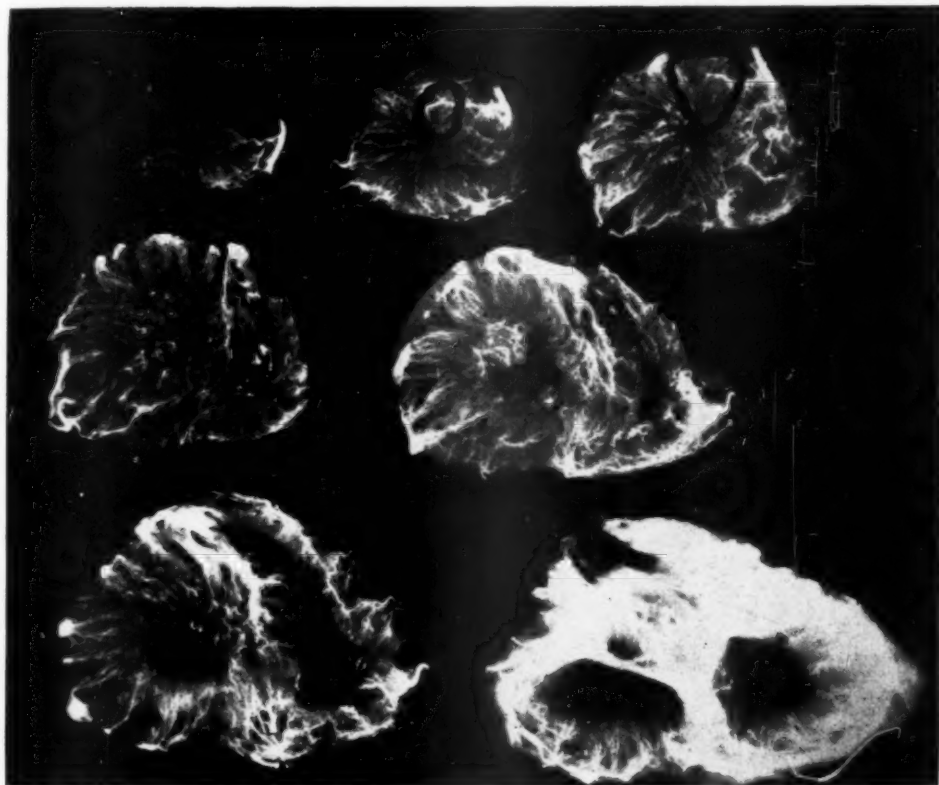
Roentgenogram of the heart of Case 6 with infarct outlined in black.
